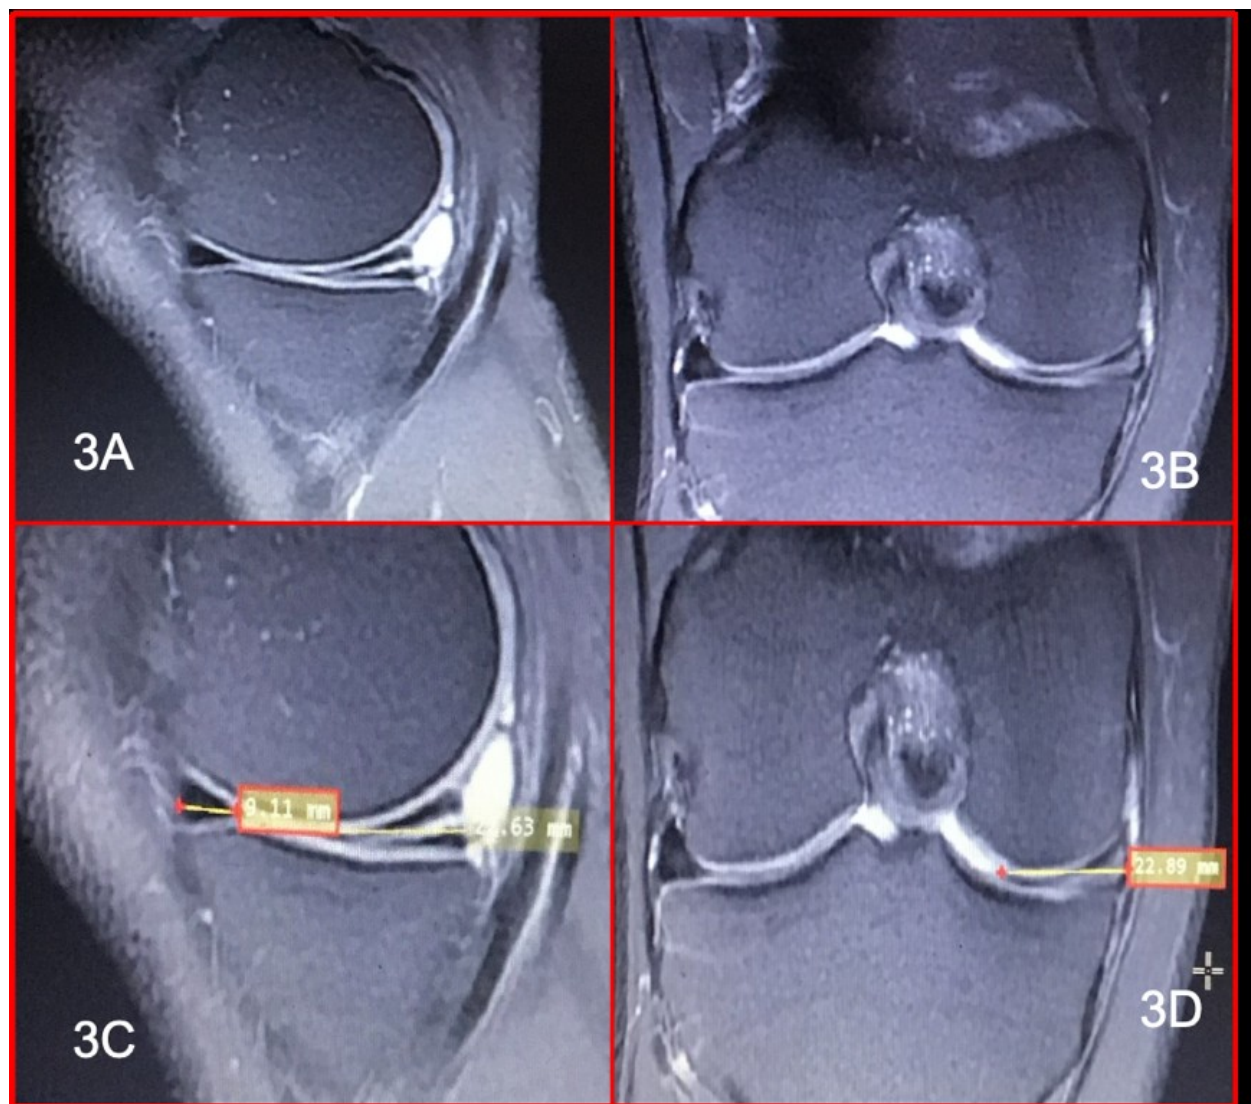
MRI appearance of a complete undisplaced horizontal cleavage tear of the posterior horn of the medial meniscus with a multiloculated parameniscal cyst. Sagittal T2 FS (3A) and coronal PD FS (3B) images demonstrating the tear and adjacent parameniscal cyst.
